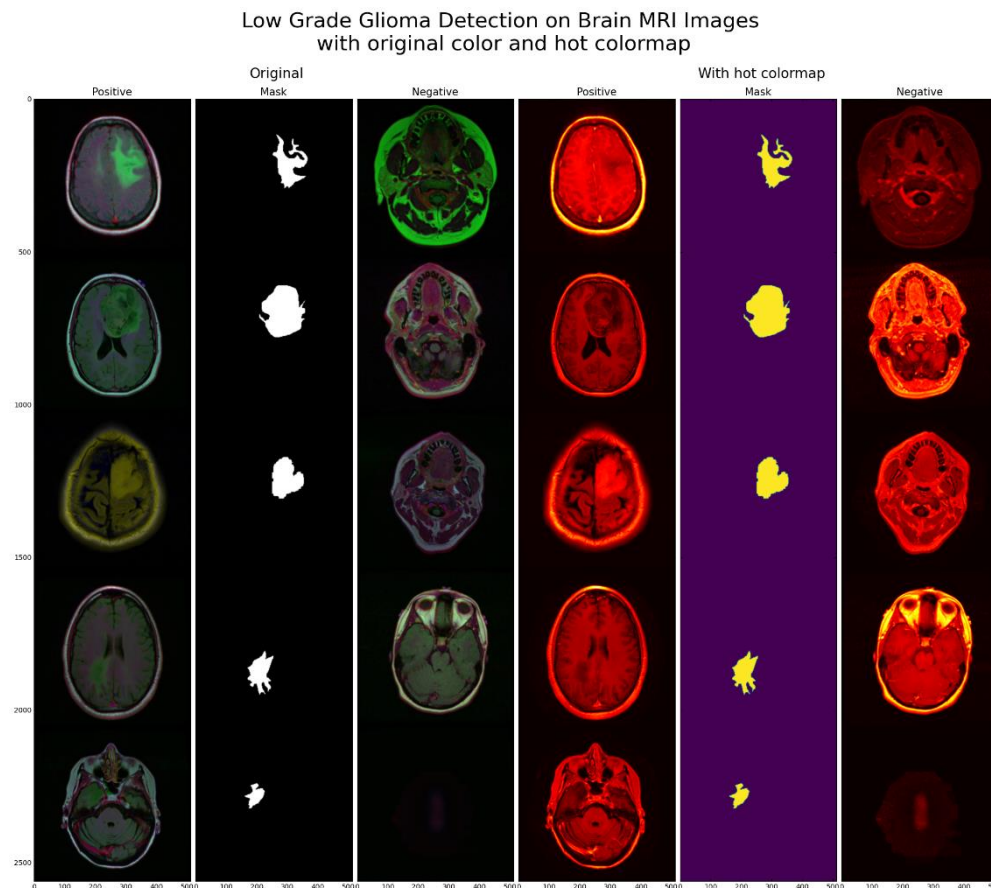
Low-Grade Glioma Detection on Brain MRI Images with original color and hot colormap
